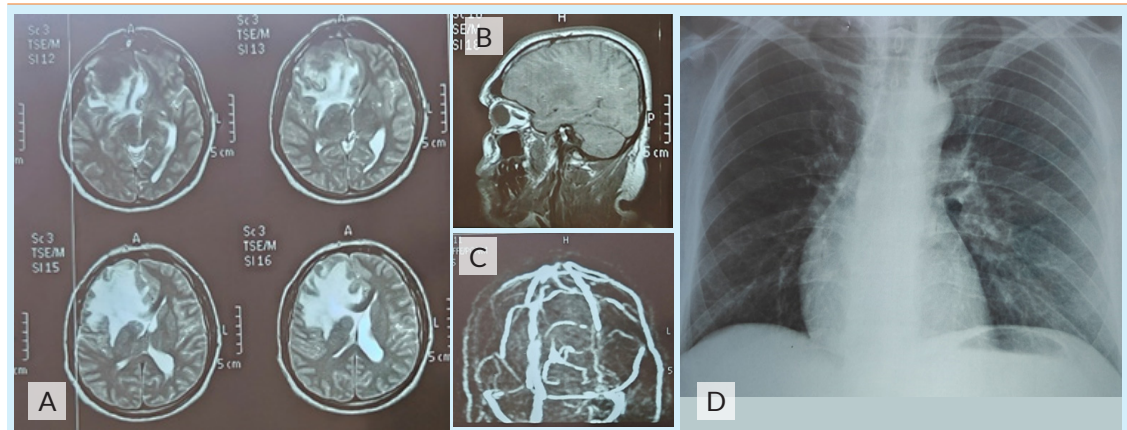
(A) & (B) MRI pictures show an enhancing right frontal dural-based lesion measuring 60*57*26mm associated with vasogenic oedema in the right frontal lobe, causing a mass effect on the ipsilateral lateral ventricle with a midline shift of 15 mm and mild dilatation of the contralateral lateral ventricle with normal posterior fossa. (C) Normal MRV study. (D) Normal posteroanterior view chest X-ray of the same patient.
